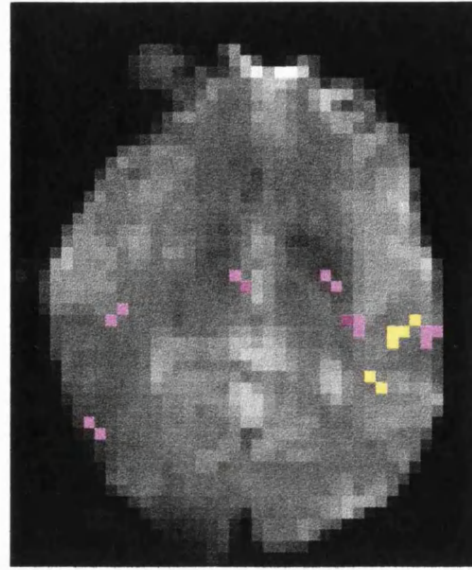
DWI (right) activation map. Pixels with significant change are shown in yellow (increased diffusion) and pink (decreased diffusion).
